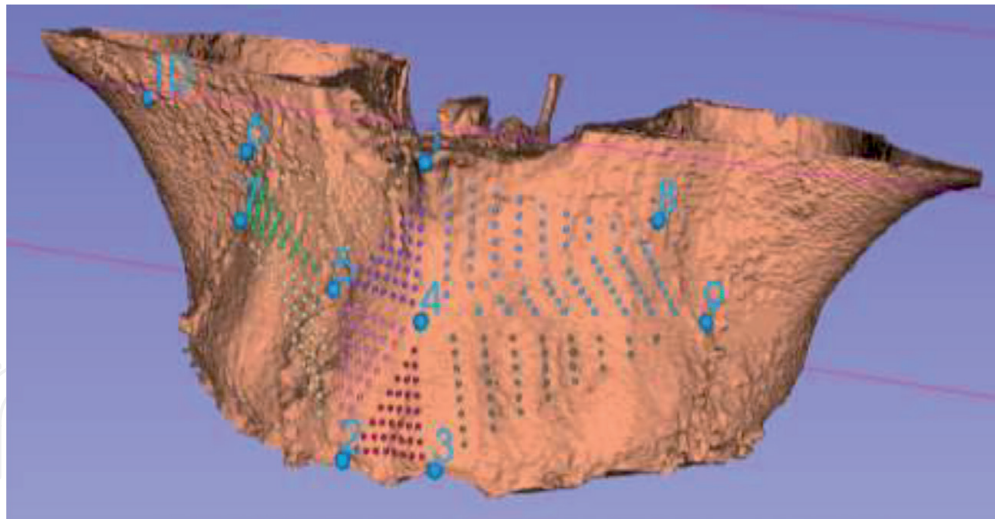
Using CBCT data, the maxillary complex has been rendered in 3D virtual space and dense correspondence of (colored) landmarks has been computed using the ten homologous landmarks (1–10).
